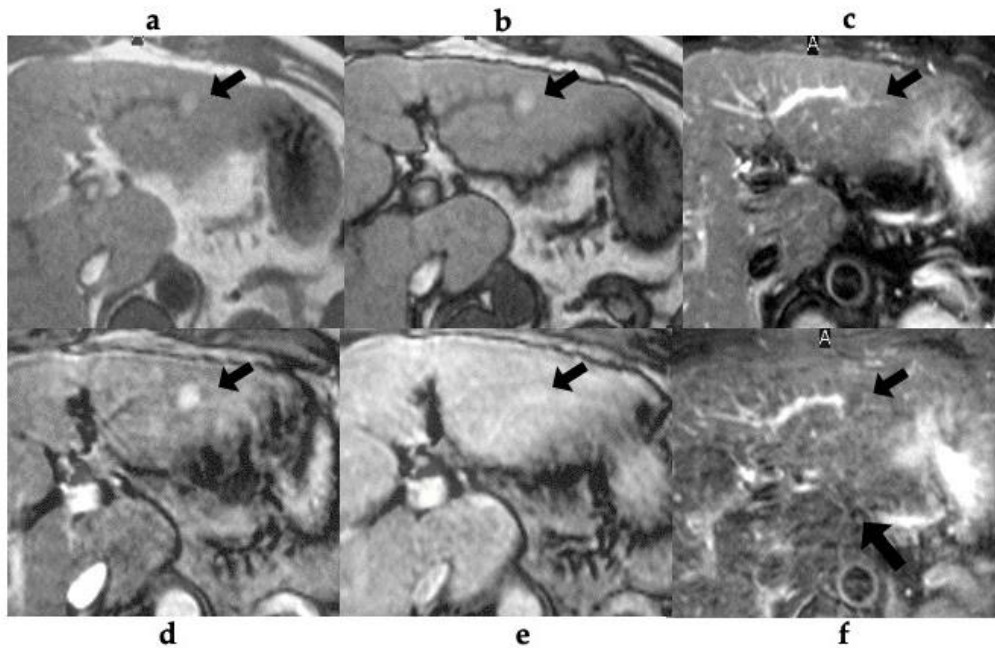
58-year-old man with alcoholic liver cirrhosis (patient no. 5). (a-b) T1-weighted gradient-echo (GRE) MR (a; in-phase, b; opposed-phase) image shows a small and high-signal-intensity nodule (arrow) in the lateral segment. (c) T2-weighted fast spin-echo MR image shows iso intensity nodule (arrow). Gadolinium-enhanced T1-weighted GRE MR imaging obtained during the (d) arterial- and (e) portal-venous phase reveals a nodule with arterial phase hyperenhancement (arrow) and without washout (arrow). (f) The SPIO-enhanced T2*-weighted GRE MR image shows the lesion as a low-signal intensity nodule (arrow) with SPIO-uptake compared with the surrounding liver parenchyma.
